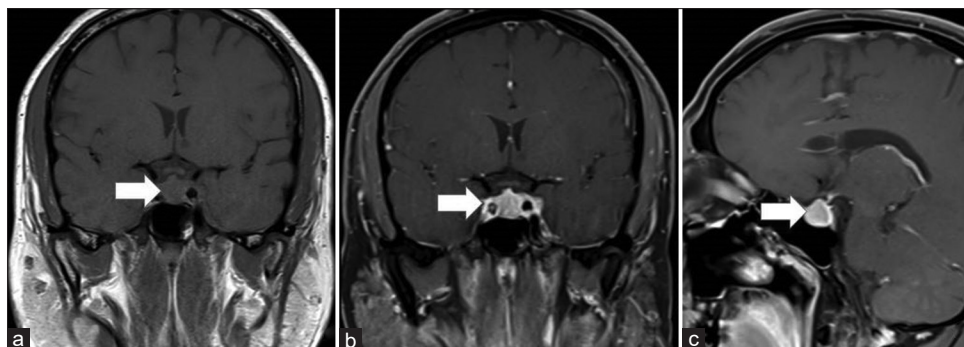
(a) T1-weighted image (coronal section) showing bulky left cavernous sinus with isointense signal, (b) T1 fat sat post-contrast image (coronal) showing pituitary enlargement and asymmetric soft tissue prominence, and contrast enhancement in the left cavernous sinus, (c) Post-contrast T1-weighted sagittal image showing pituitary hyperplasia
